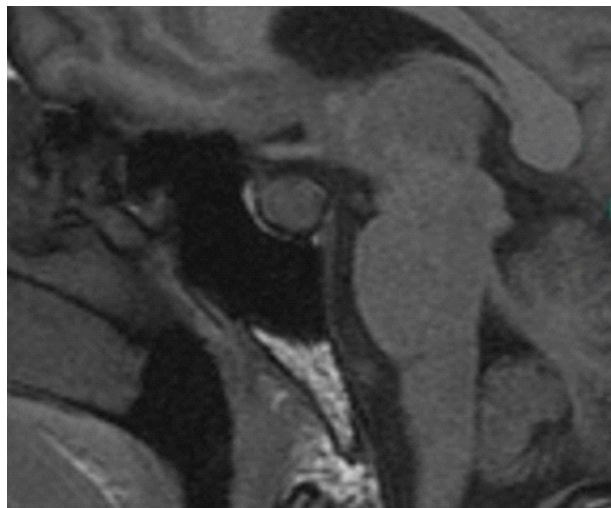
Case 2: IV Contrast MRI performed preoperatively on a 45-year-old acromegalic male with intrasellar tumor of 1.5 by 1.0 cm contacting the optic chiasm and pituitary stalk (sagittal plane)
